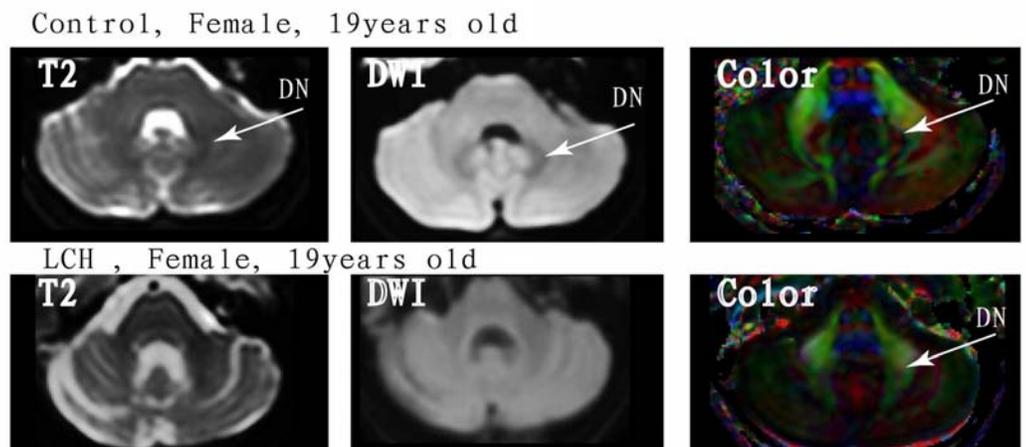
T2-weighted, average diffusion weighted, and color maps of a control and a LCH patient. DN was supposed to mixed red color between the green colors of the cerebellar peduncles in colormap.
